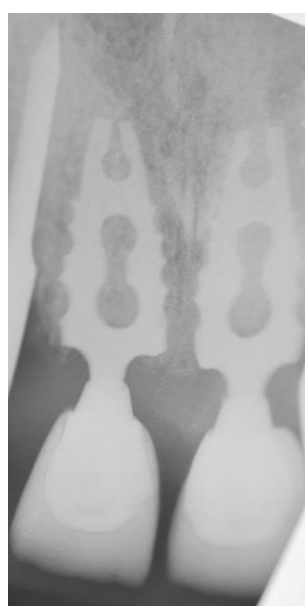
Radiograph of two Pasqualini single-blades with single prosthetic crowns 23 years after insertion and immediate loading (2002-2025).
